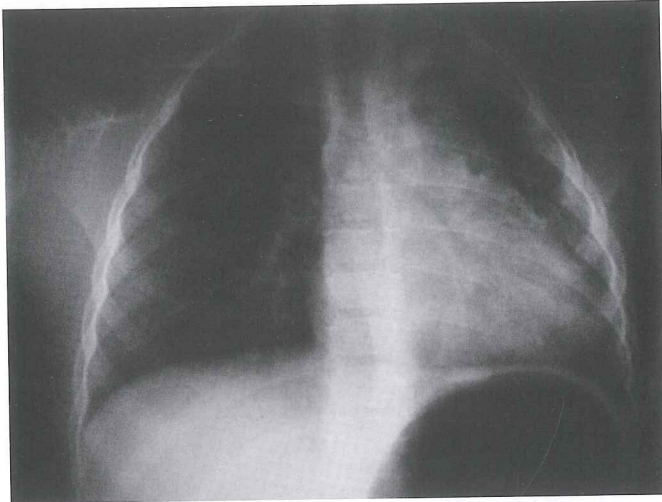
On chest radiograph, left lower lobe infiltration and left mediastinal shift were observed.
